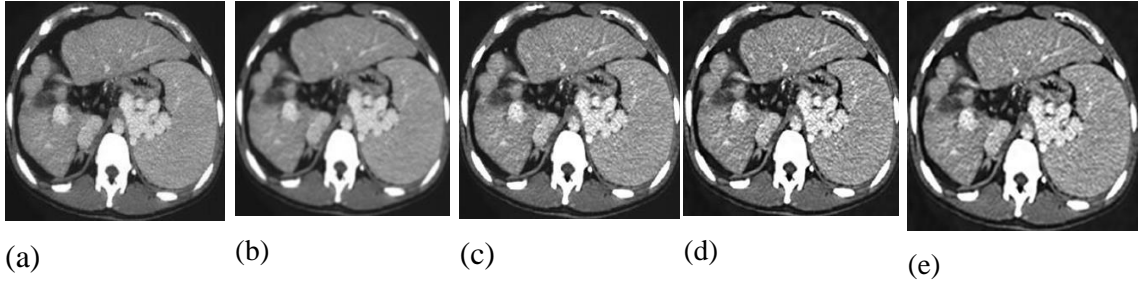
(a) Original test CT image. (b) Shearlet-based enhanced CT image (c) Adaptive morphology TopHat transform-based enhanced CT image (d) DCT-based enhanced image (e) Final output enhanced CT image
